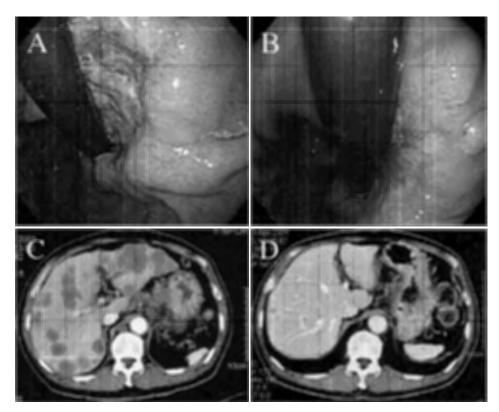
Case 2. A Endoscopic view of a Borrmann type 2 tumor in the upper portion of the stomach before chemotherapy. B The tumor decreased in size and formed an ulcer scar after the treatment. Computed tomography of multiple liver metastases in case 2, C before and D after undergoing the combination chemotherapy
